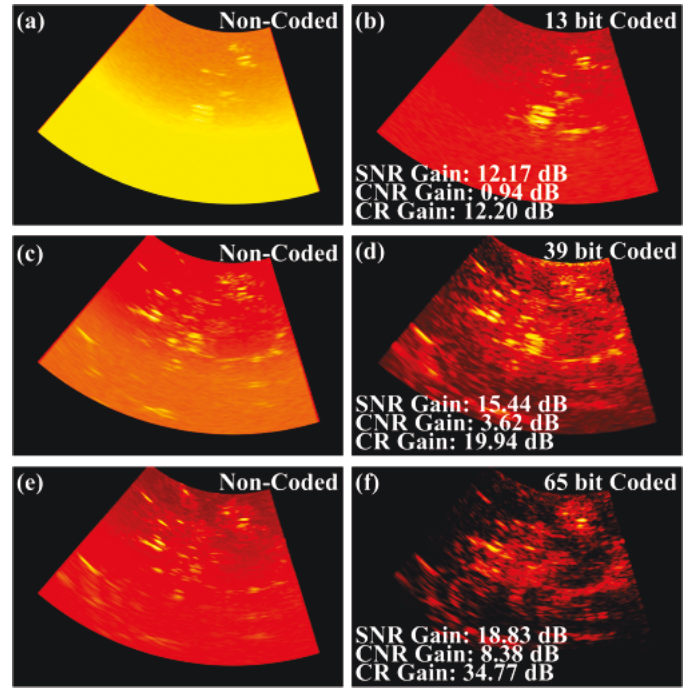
Transcranial power Doppler in Subject 3 with clutter filtering performed via SVD. Non-coded excitation images are shown on the left in panels (a), (c), and (e). Their respective coded excitation pairs are shown on the right in panels (b), (d), and (f) which correspond to code lengths of 13, 39, and 65, respectively. The coded excitation panels also have the SNR gain, CNR gain, and CR gain indicated in the bottom left corner. All images are shown on the same 40 dB dynamic range.
